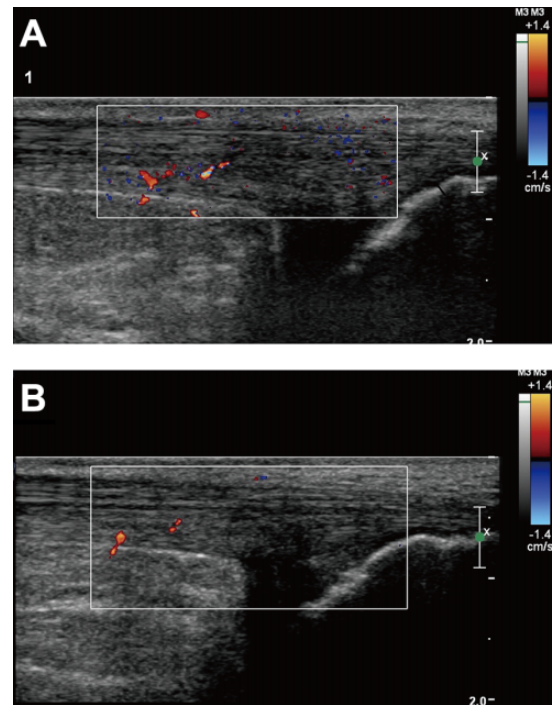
(A) Color Doppler shows no vessels in the insertion of the Achilles tendon, while there were numerous vessels near the insertion site before therapy. (B) After ESWT therapy, there were no neovascularizations in the insertion site, and the revascularization decreased near the insertion site compared with ultrasonographic images before the treatment. ESWT, extracorporeal shock wave therapy.
